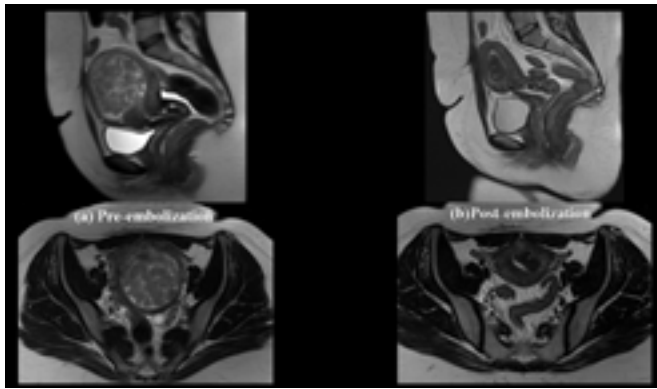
a) Pre-embolization MRI demonstrates enlarged uterus with solitary submucosal cum intramural (FIGO-1) fibroid arising from left anterolateral wall causing distortion & displacement of the endometrium. b) On post-embolization MRI, there is almost 70% volume reduction of uterus & 90% volume reduction of fibroid.
